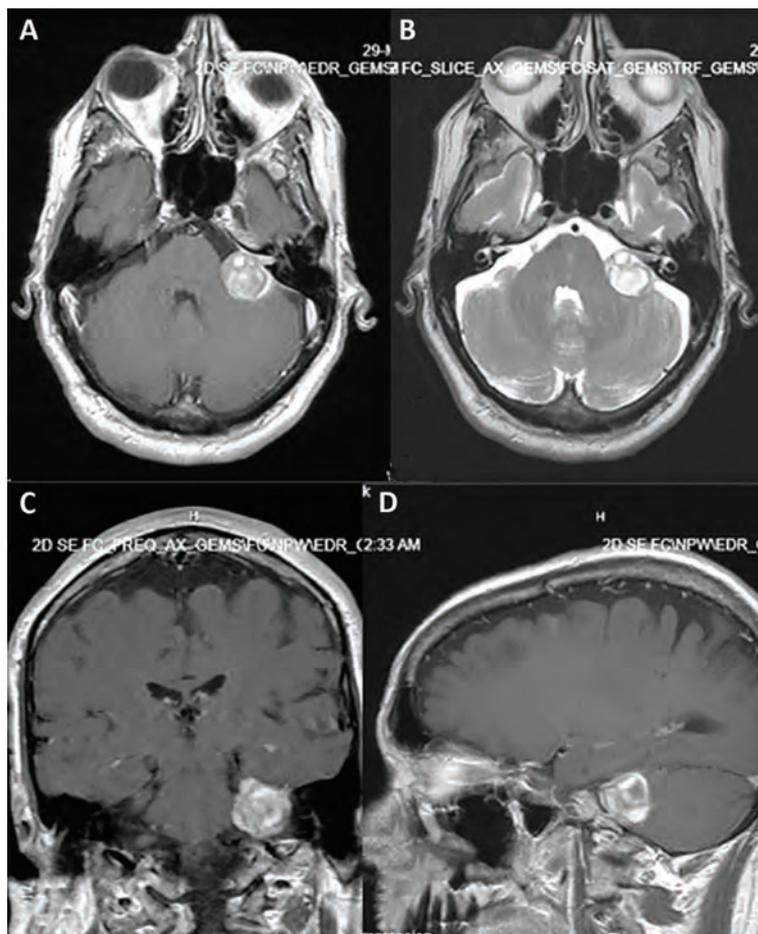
Preoperative head MRI of a 56-year-old patient with acute onset of left CN-VII palsy. (A) Axial T1-post contrast MRI, (B) axial T2 MRI, (C) coronal T1-post contrast, and (D) sagittal T1-post contrast head MRI shows left sided VS with signs of intratumoral bleeding and effacement of the pons.
